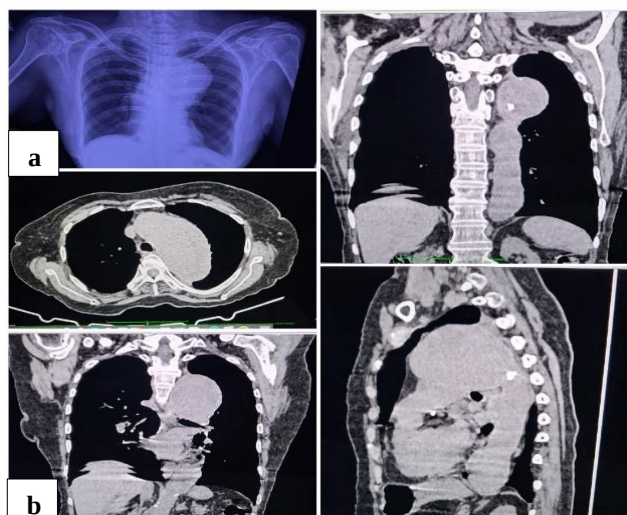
(a) Chest X-ray - showing dilatation of the aorta, and (b) CT- chest- showing multiple aneurysms in the aorta.
